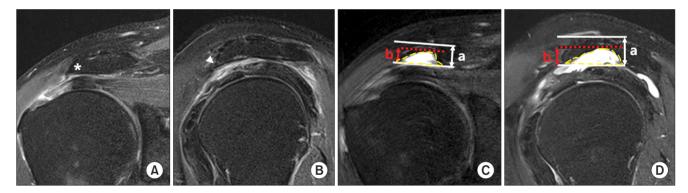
Severe acromial cupping of the acromial undersurface. (A) Preoperative T2-weighted oblique coronal magnetic resonance (MR) image showing a mild lateral traction type spur (asterisk). (B) Preoperative T2-weighted oblique sagittal MR image showing an anterior bird beak spur (arrowhead). (C) Postoperative T2-weighted oblique coronal MR image showing severe acromial cupping (yellow dotted line). The depth of acromial cupping (b) versus acromial height (a) was $\geq 1/3$. (D) Postoperative T2-weighted oblique sagittal MR image showing severe acromial cupping (yellow dotted line).
